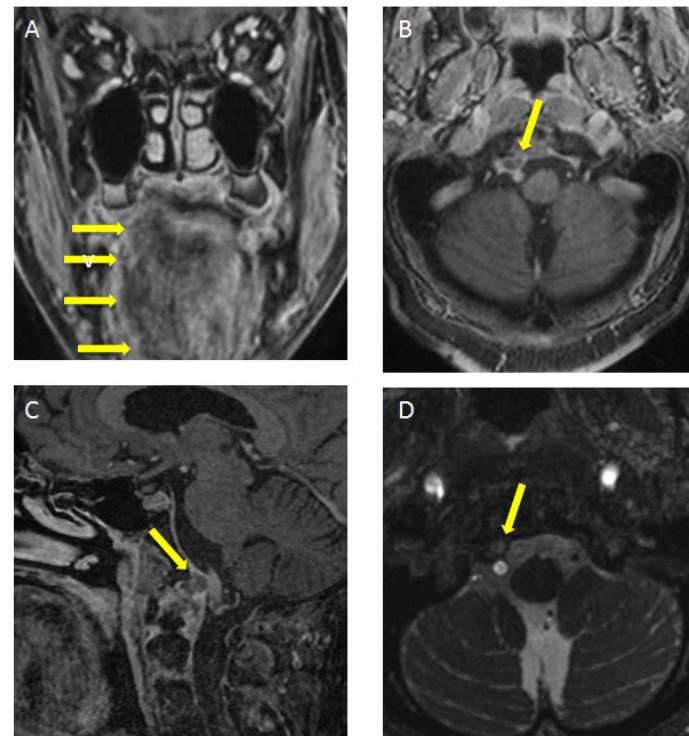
(A), (B) and (C) post-gadolinium T1 fat saturation in the coronal, axial and sagittal planes; (D) axial 3D-CISS MRI. Right hemitongue fatty degeneration due to atlantoaxial arthrosynovial cyst compression and hypoglossal nerve palsy.
